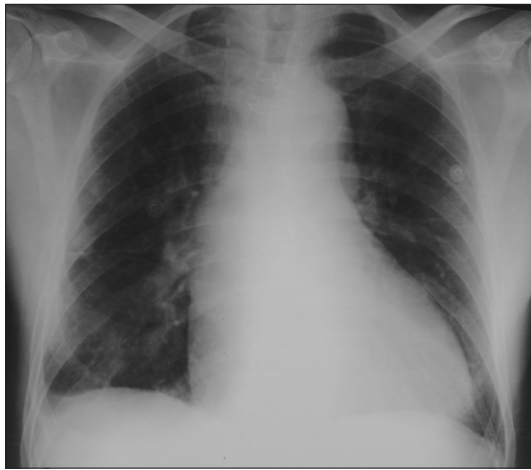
Chest X-ray (anteroposterior view) demonstrating cardiomegaly
